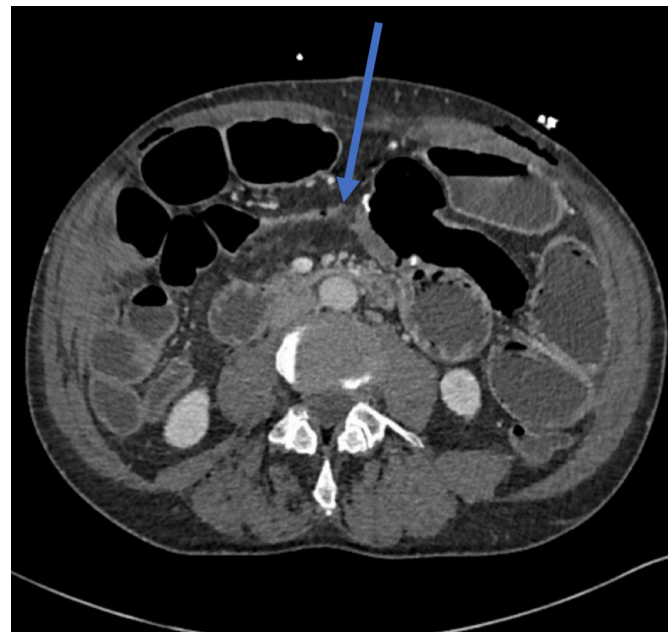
Abdominal and Pelvic CT Scan on POD 4. Published with Permission.
